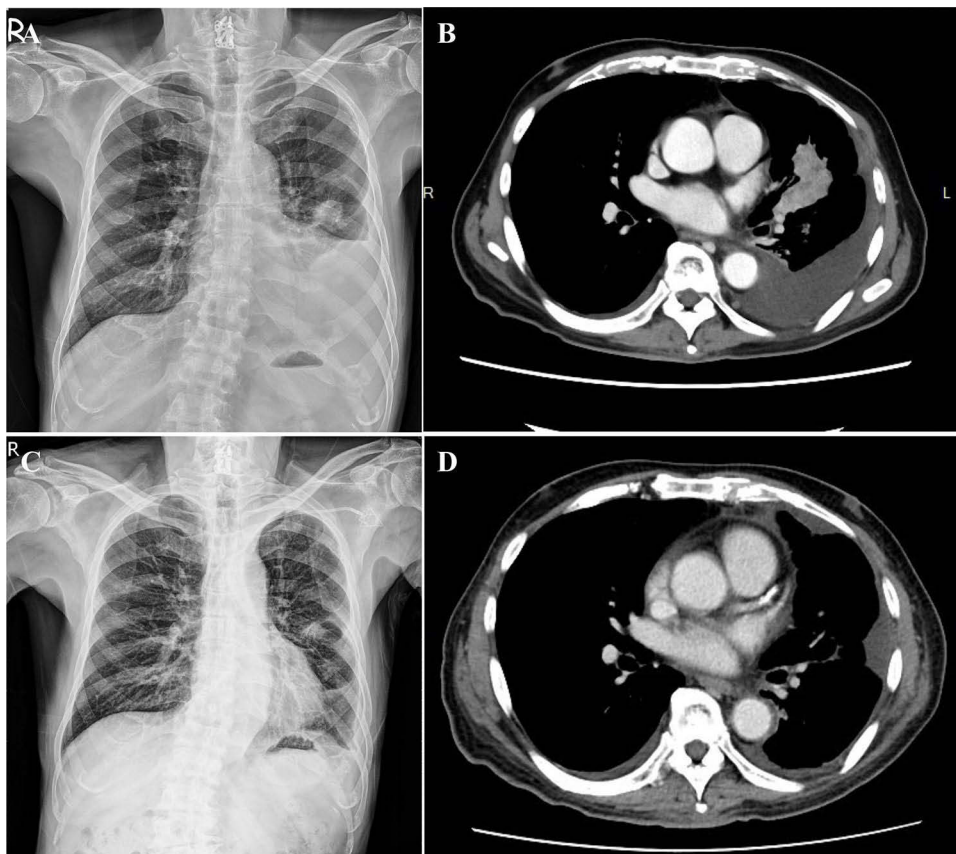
Radiographic findings before and after chemotherapy treatment. (A) Chest X-ray and (B) CT scan demonstrated an enlarged primary lesion in the left upper lobe with associated pleural effusion. (C) Chest X-ray and (D) CT scan revealed a decreased size of the tumor in the left upper lobe with diminished pleural effusion after chemotherapy.
